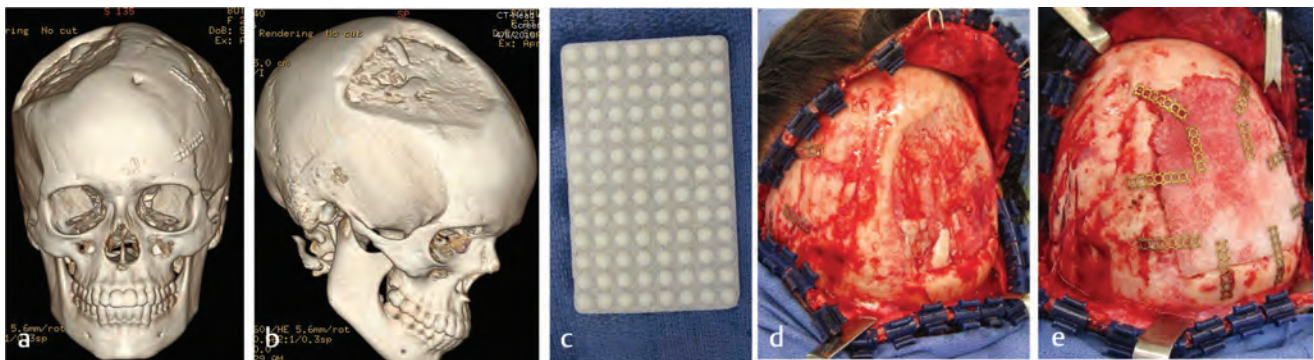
An adolescent girl with a partial-thickness parietal defect managed by onlay cranioplasty using porous polyethylene. (a,b) Preoperative CT images. (c) Porous polyethylene. (d) Intraoperative view of defect (e) after onlay cranioplasty.
